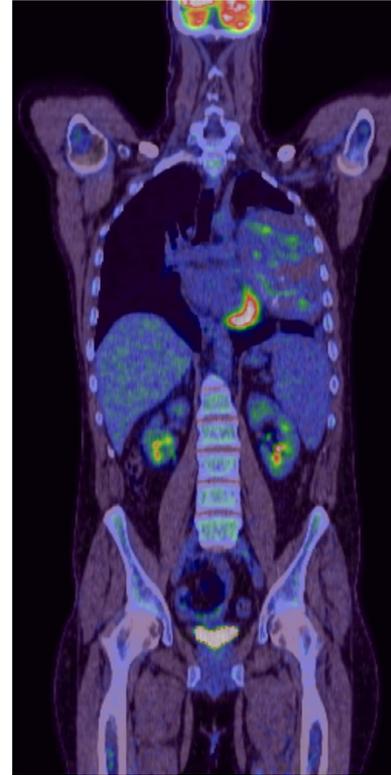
PET post 4 cycles of escalated, intensive chemotherapy shows mild further reduction in dimensions of mediastinal mass. However there is increase in SUV from previous PET, suggesting Deauville 4 response
